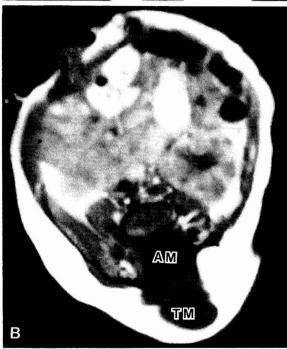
Case 1. Sagittal (A) and axial (B) T1-weighted MRI scans demonstrating terminal myelocystocele. The conus (C) is low-lying, and there is an anterior meningocele (AM) as well as a terminal cyst (TM) surrounded by fat.
